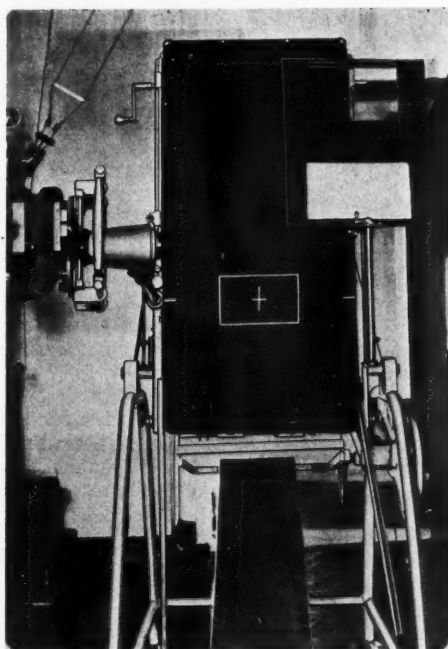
Genito-urinary radiographic table in vertical position, showing 5 × 8-inch scribed central area. The inclined plane is placed beneath the apparatus. Note the device for shielding one-half of the 8 × 10-inch cassette (placed in the upper right-hand corner of the apparatus), showing protective sheet lead in front and sheet metal back mounted upon a wooden frame having a metal bar at the upper end which facilitates its removal from the grid tray.
